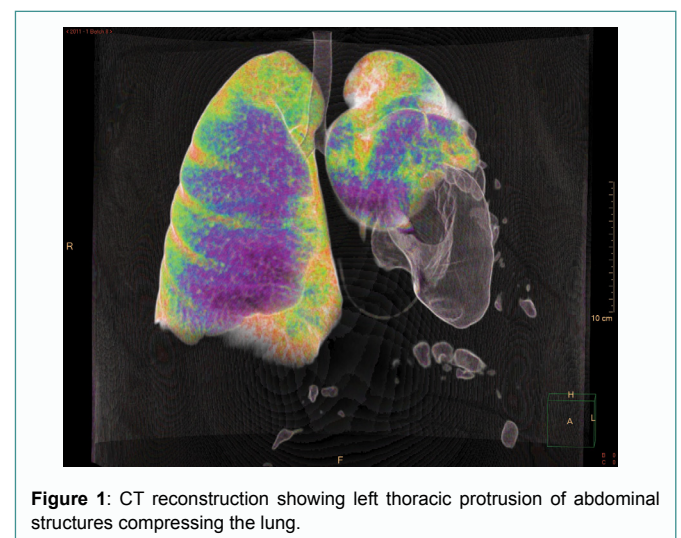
CT reconstruction showing left thoracic protrusion of abdominal structures compressing the lung.
